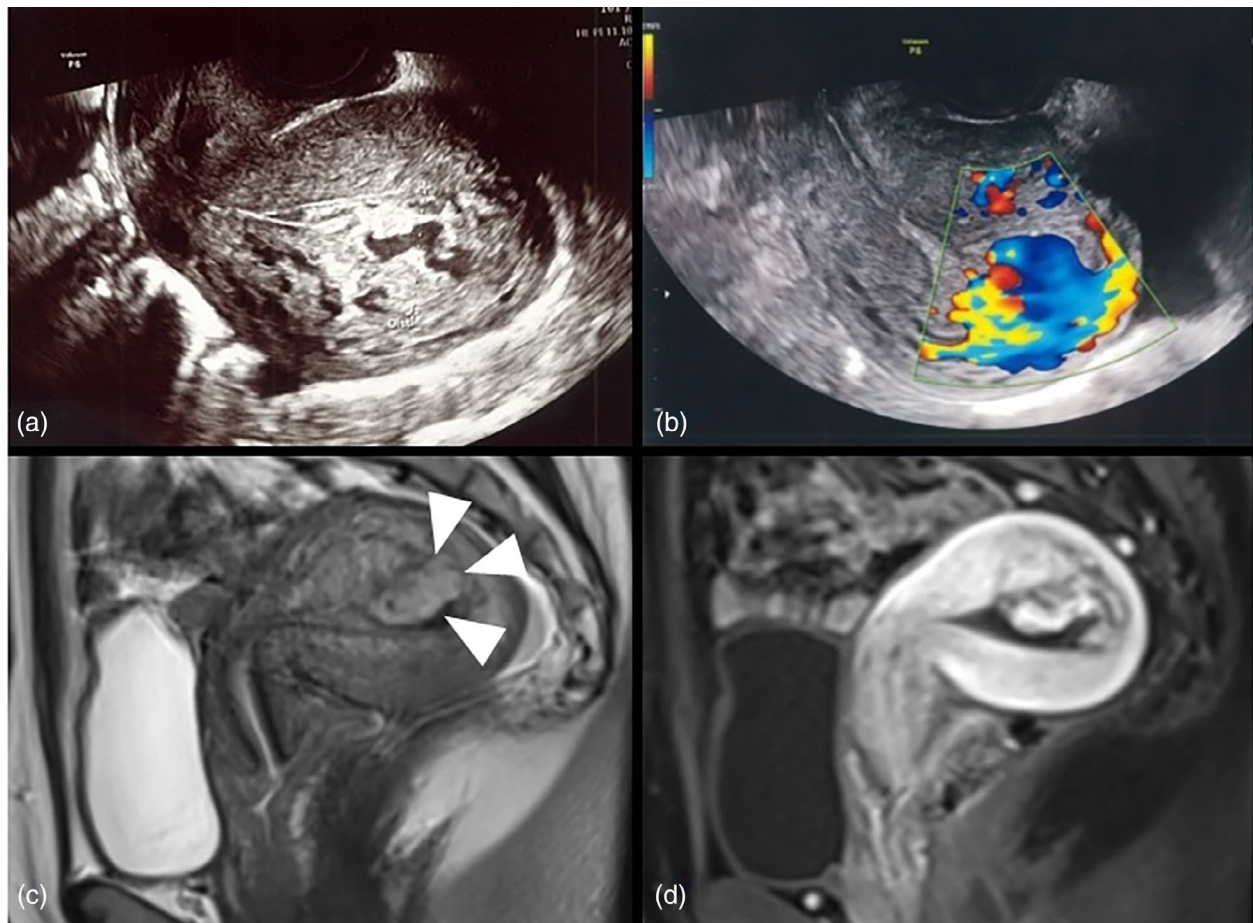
Ultrasonographic and magnetic resonance (MR) images obtained 2 weeks after the dilatation and curettage. (a) Transvaginal grayscale ultrasonogram shows a 2.9 cm mass in the uterus. (b) Transvaginal color Doppler ultrasonogram shows abnormal blood flow to the mass. (c) Sagittal T2-weighted MR image shows a $2.2 \times 2.9 \times 2.6$ cm mass (arrowheads) occupying the uterus. (d) Contrast-enhanced MR image of the mass
